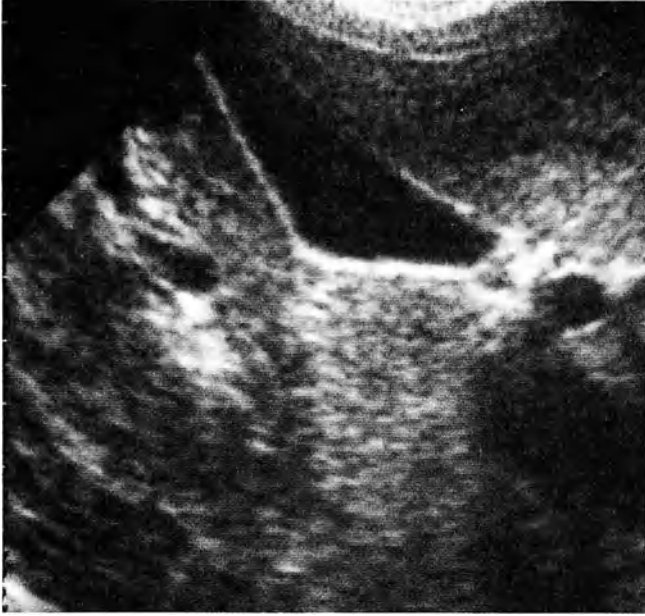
Abdominal ultrasound showing normal gallbladder
